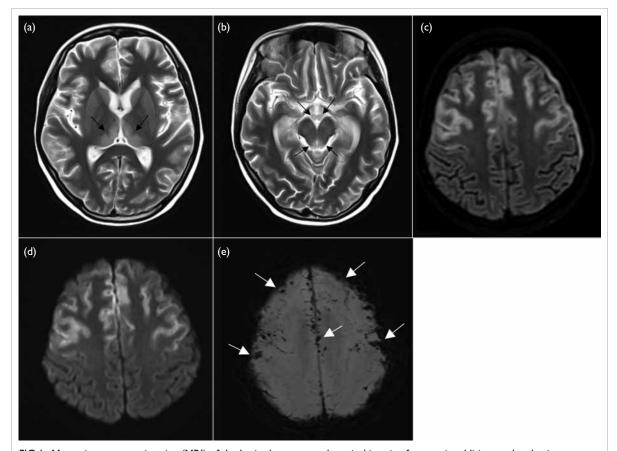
Magnetic resonance imaging (MRI) of the brain demonstrated atypical imaging features in addition to the classic findings in Wernicke's encephalopathy. Axial T2-weighted MRI showing abnormal symmetrical T2-weighted signals in bilateral dorsomedial thalami (a) and periaqueductal grey, tectal plate of the midbrain and mammillary bodies (b), which are typically seen in Wernicke's encephalopathy (black arrows). (c) Axial fluid-attenuated inversion recovery MRI showing abnormal high signal involving cortices of bilateral frontal lobes. (d) Diffusion-weighted imaging (b value=1000 s/mm²) showing restricted diffusion in bilateral frontal lobe cortices. (e) Susceptibility-weighted imaging showed blooming artifacts in bilateral frontal lobe cortices, indicating microhaemorrhage (white arrows). The involvement of frontal lobe cortices with haemorrhage is an atypical imaging feature and more commonly seen in non-alcoholic Wernicke's encephalopathy
